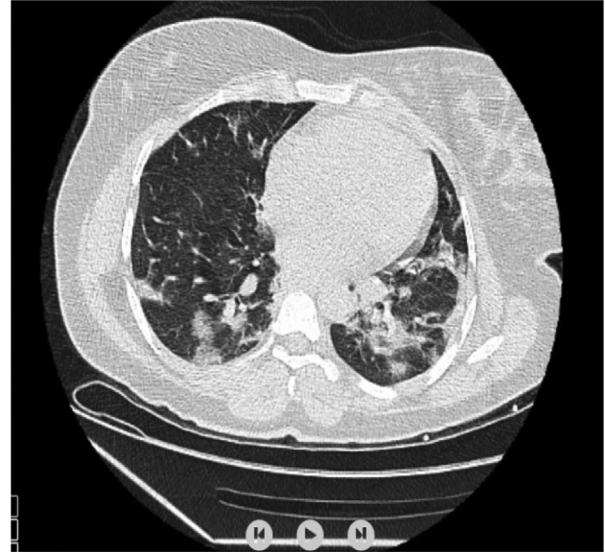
Case 4' CT scan shows opacities on admission
